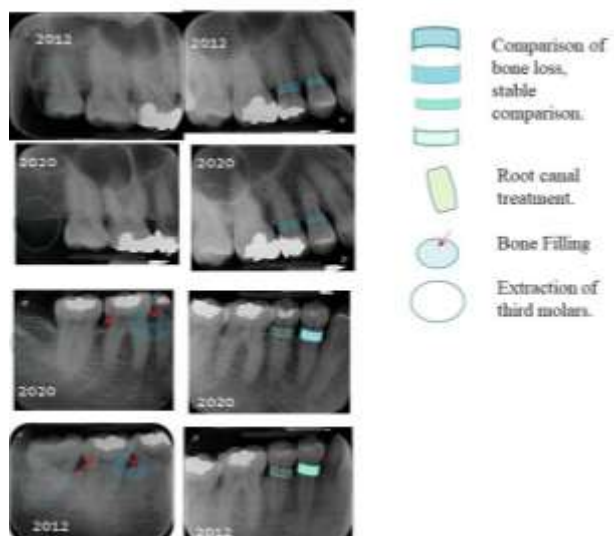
A comparison of the bone alveolar condition and radiographic changes of left molars and premolars from 2012 to 2020 was presented, in which bone filling was also observed.
